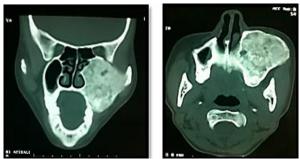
CT shows expansile ground glass bony mass involving the anterior, mesial and distal walls of maxilla
